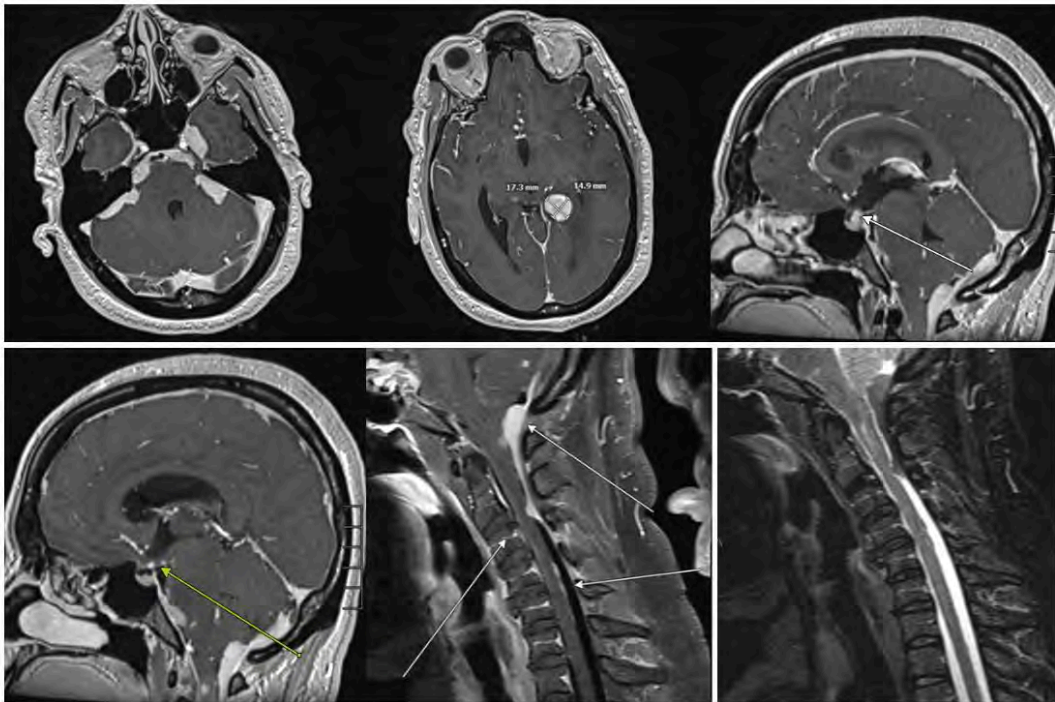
Contrast-enhanced brain and cervical spine MRI showing nodular leptomeningeal enhancement at the skull base and basal cisterns, extending to C3, with severe C2–C3 cord compression, upper cervical cord edema, and an enhancing left parietal nodule.
